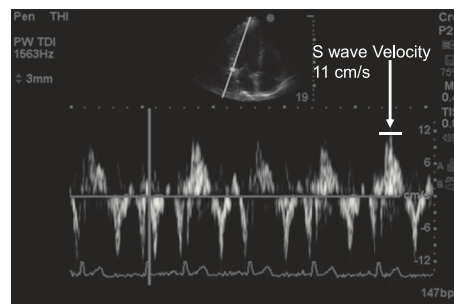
Apical four-chamber view showing TDI measurement of the lateral tricuspid valve velocity. Normal values are >10 cm/s. Reduced velocity suggests right ventricular systolic dysfunction. See Figure 2 legend for expansion of abbreviations.
